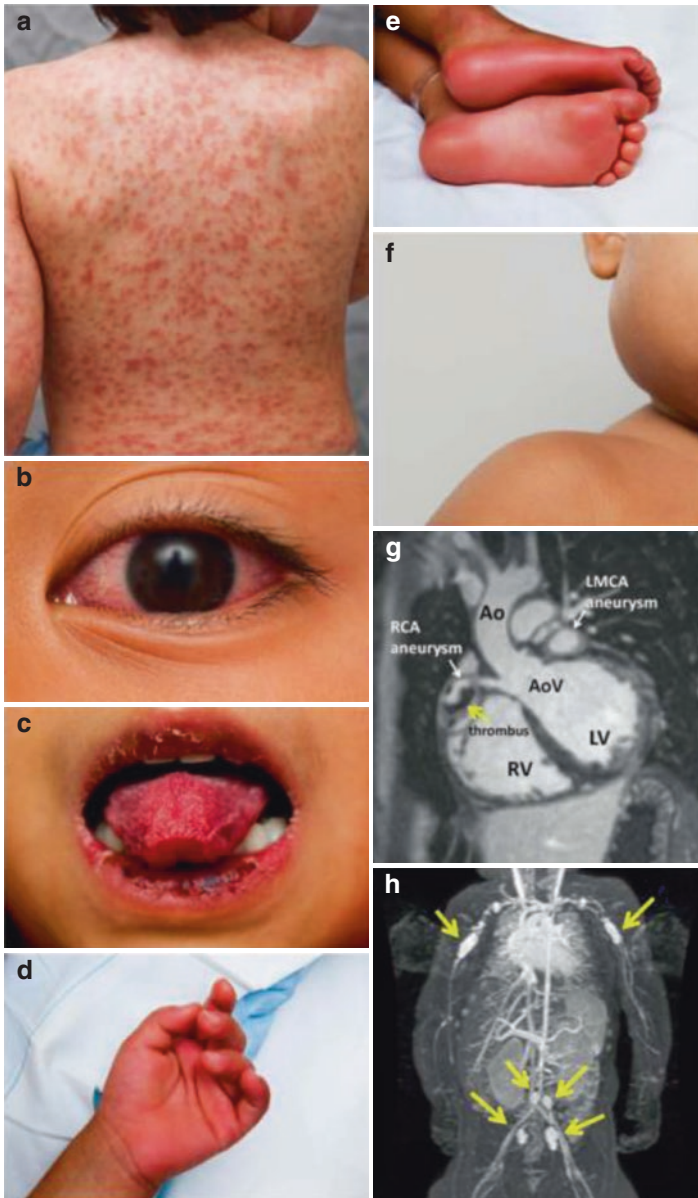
Classic clinical features of Kawasaki disease. (a) Rash characterized by maculopapular, diffuse erythroderma, or multiforme-like erythema. (b) Bilateral conjunctivitis and bulbar conjunctival injection without exudate. (c) Oral changes include cheilitis (erythema and cracking of the lips), strawberry tongue, and erythema of the oral and pharyngeal mucosa. (d) Palmar and (e) plantar erythema, which is usually accompanied by swelling and resolves with subsequent periungual desquamation in the subacute phase. (f) Cervical adenopathy, which is usually a unilateral node no more than 1.5 cm in diameter. (g) Coronary artery aneurysm in the right coronary artery with a nonocclusive thrombus and the left main coronary artery demonstrated on magnetic resonance imaging. Ao, aorta; AoV, aortic valve; LV, left ventricle; RV, right ventricle. (h) Peripheral artery aneurysms in the axillary, subclavian, iliac, and femoral arteries. Images reused with permission from American Heart Association
